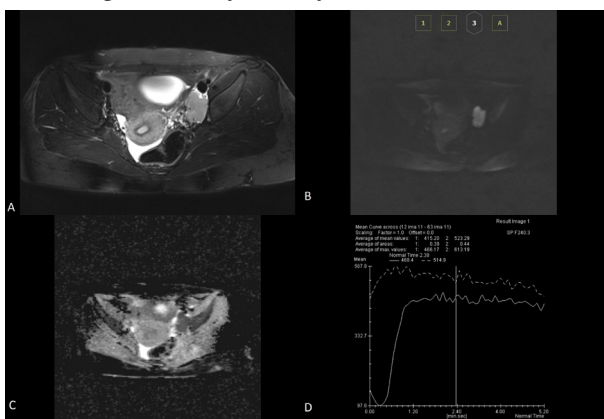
A 51-Year-Old Female with Broad Ligament Myoma Appeared as Right Adnexal Mass on Ultrasound. Right Ovary Is Not Seen On Ultrasound. A. Axial fast spin-echo T2-weighted image shows a lobulated low signal intensity mass with internal high signal area, adjacent to the uterus. B. Axial DWI obtained at b =1000 s/mm<sup>2</sup> shows low signal intensity in the periphery and high signal intensity in the central portion of the mass. C. Axial ADC map demonstrates that the high signal intensity of the central portion was due to T2 shine-through effect. The mean ADC value of the peripheral part was 1.3×10<sup>-6</sup> mm<sup>2</sup>/s. D. Time-signal intensity curve derived from DCE-MR was type 2 in relation to myometrium
